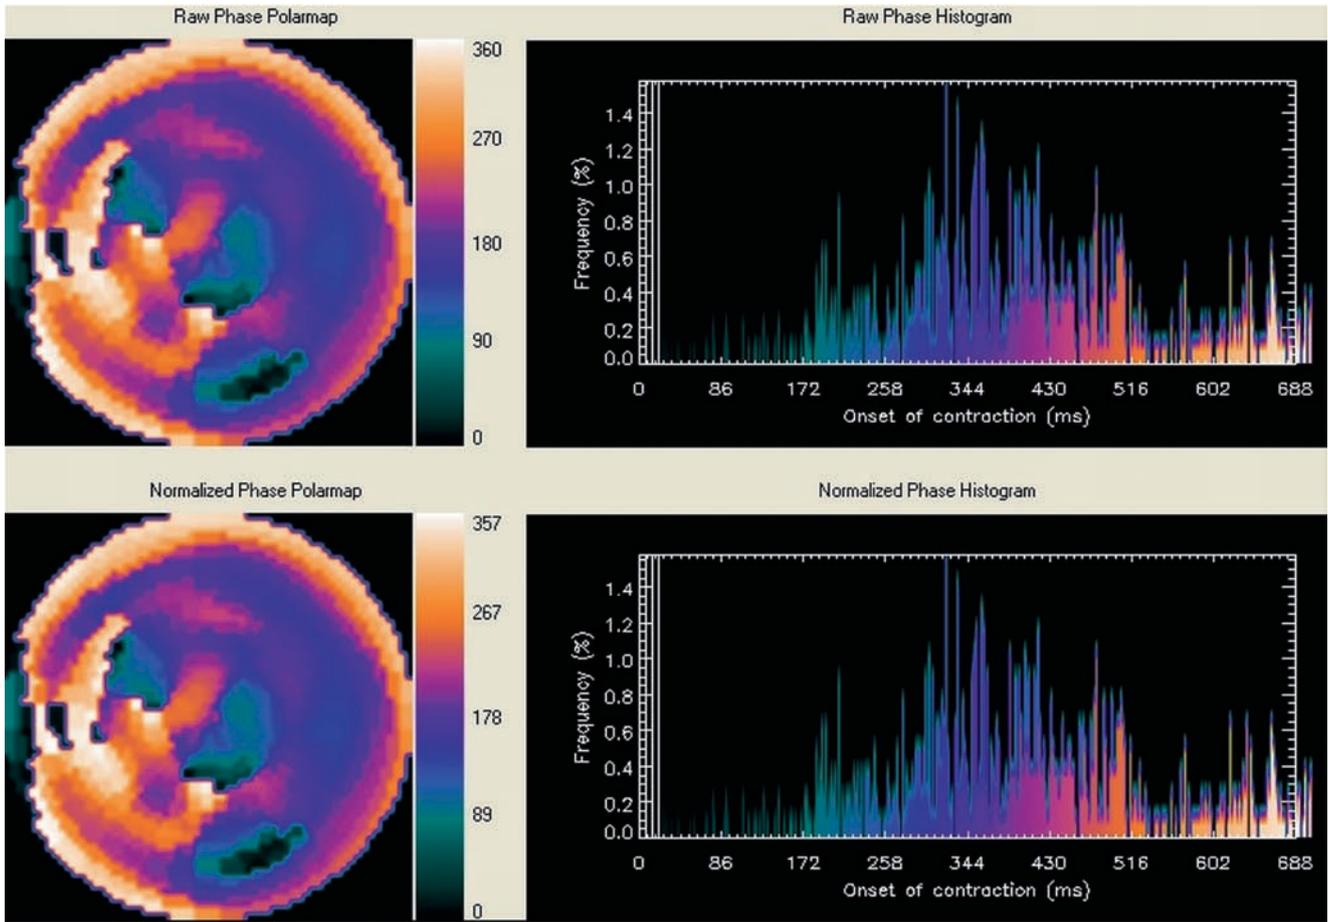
Example of phase analysis with gated myocardial perfusion SPECT in a patient with extensive LV dyssynchrony. The heterogeneous phase angle distribution is reflected in the non-normalized
